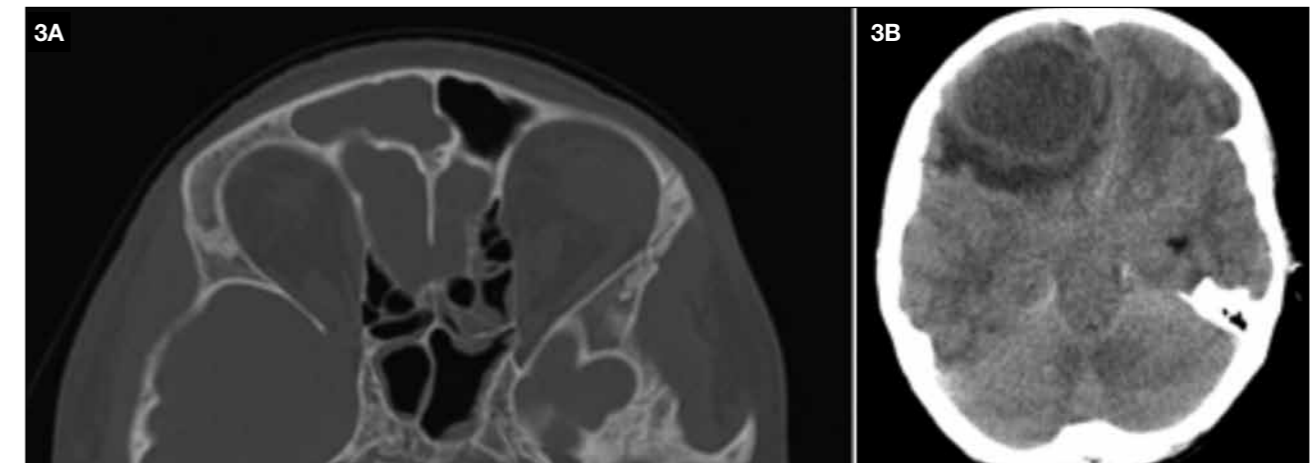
A) Axial CT scan showing an opacified frontal sinus. In this case dehiscence of the posterior table of the frontal sinus was also noted, with direct spread of the infection. B) Axial CT scan with contrast showing a frontal lobe abscess of sinogenic origin, as a result of the frontal sinus infection
